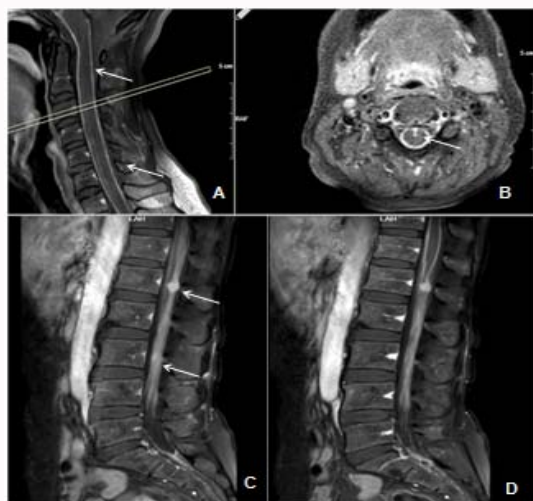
A/B: Contrast-enhanced T1-weighted sagittal and axial sections show diffuse leptomenigeal thickening and enhancement along the medulla oblongata and spinal cord. In addition, significant enhancement is observed in the anterior median fissure (arrows). C/D: In post-contrast T1-weighted sagittal sections and millimetric nodular enhancing lesions (arrows) are observed in the thecal sac at L1 and L3 levels. In addition, diffuse leptomenigeal enhancement is observed in the lumbar spine.
